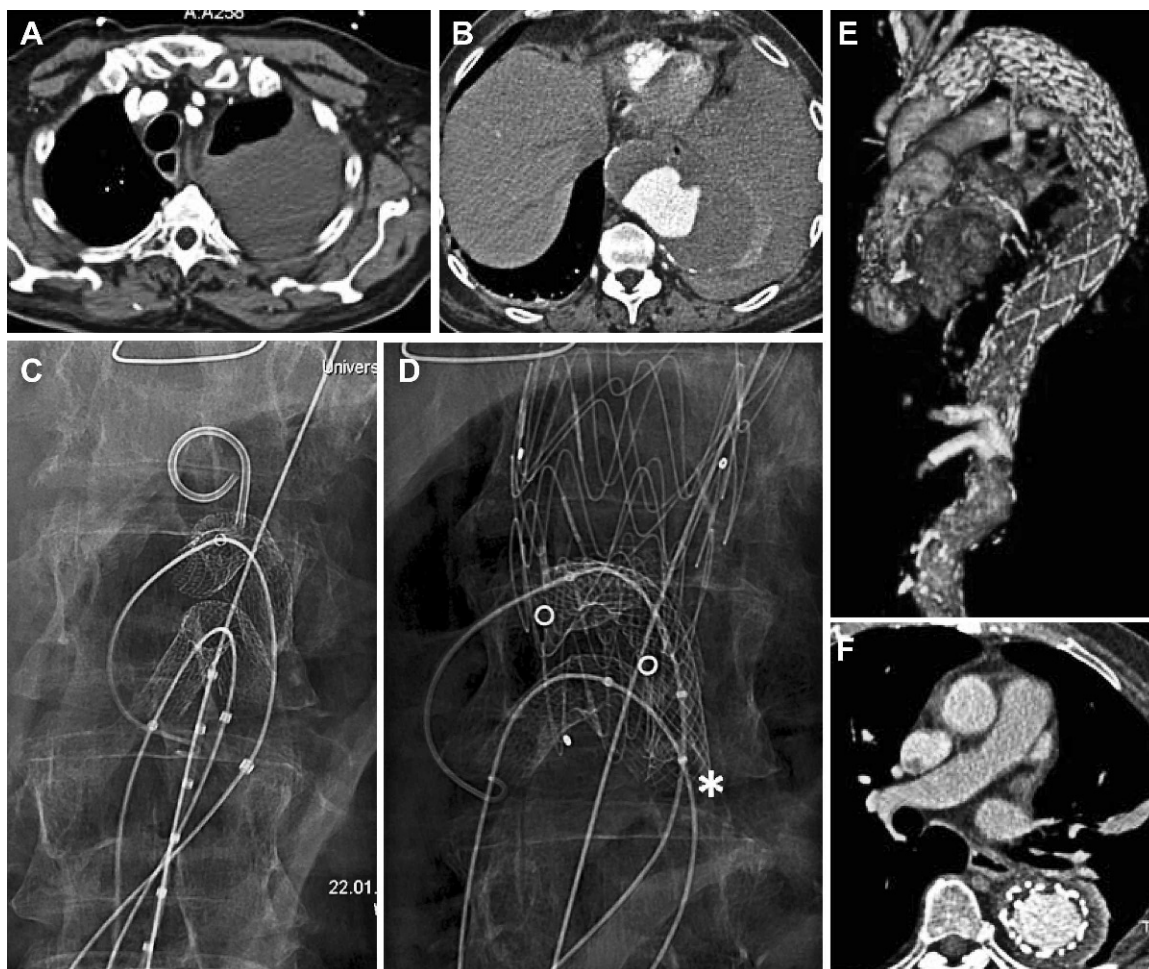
♦ (A,B) Intrathoracic hematoma extending from the apex to the diaphragm in a patient with a Crawford I TAAA (case 8). (C) Transfemoral implantation of periscope grafts in the celiac trunk and superior mesenteric artery. (D) After aortic stent-graft deployment, a pressure gradient was detected on the celiac periscope and treated with additional stenting. The asterisk marks the Wallstent. (E) CT reconstruction after endovascular repair with the MPCG technique. (F) CTA after thoracic hematoma evacuation.
